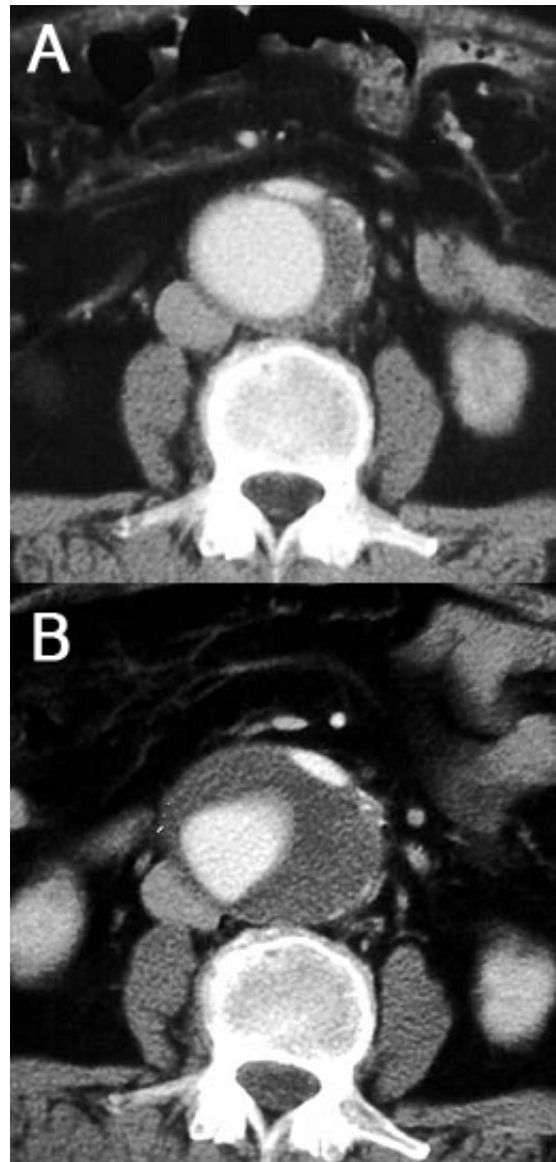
Contrast CT scan taken before (A) and 5 years after (B) the stent-graft at primary entry tear show progressive dilatation of abdominal false lumen. The maximal diameter of abdominal aorta including false lumen is increased from 4.8 x 4.3 cm to 6.5 x 5.1 cm.
